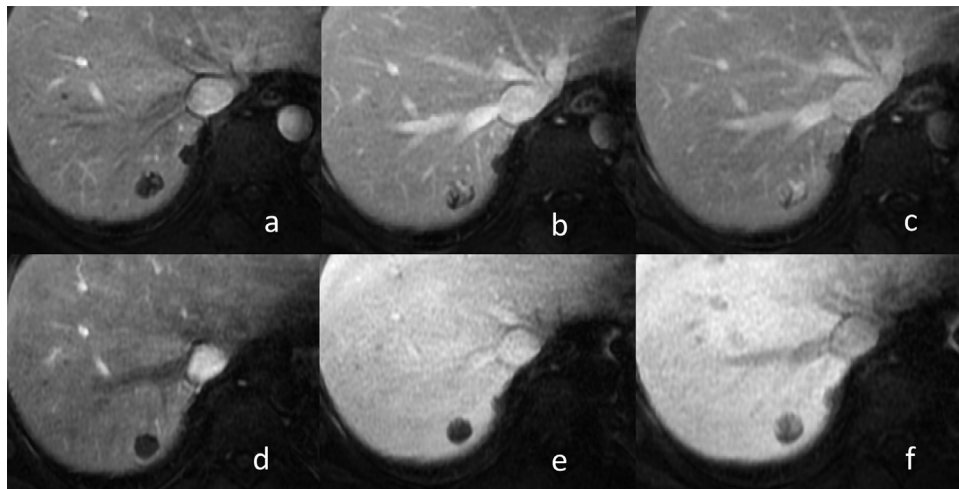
MR imaging exams in a 32-year-old man performed with gadobenate dimeglumine (a, b, c) and gadoxetic acid (d, e, f), show a cavernous hemangioma in the segment VII. At gadobenate dimeglumine enhanced MR the lesion shows peripheral globular discontinuous enhancement in the arterial phase (a), with progressive fill-in in the portal venous (b), and the 3-minute phases (c). At gadoxetic acid enhanced MR, the hemangioma is hypointense in both the arterial (d) and portal venous (e) phases, and shows only minimal centripetal fill-in in the 3-minute phase (f). Notice how the intrahepatic vessels are already hypointense due to contrast uptake. MR, magnetic resonance.
